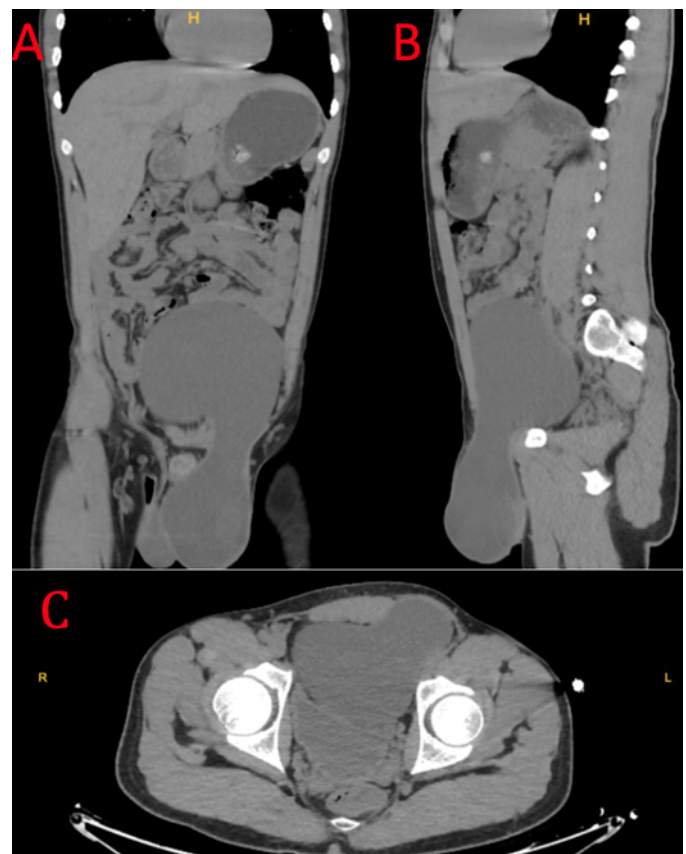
The hourglass appearance of the abdominoscrotal hydrocele sac in the coronal (A) and sagittal (B) section and the bladder displaced by the abdominal hydrocele sac in the transverse (C) section image of the computed tomography.
